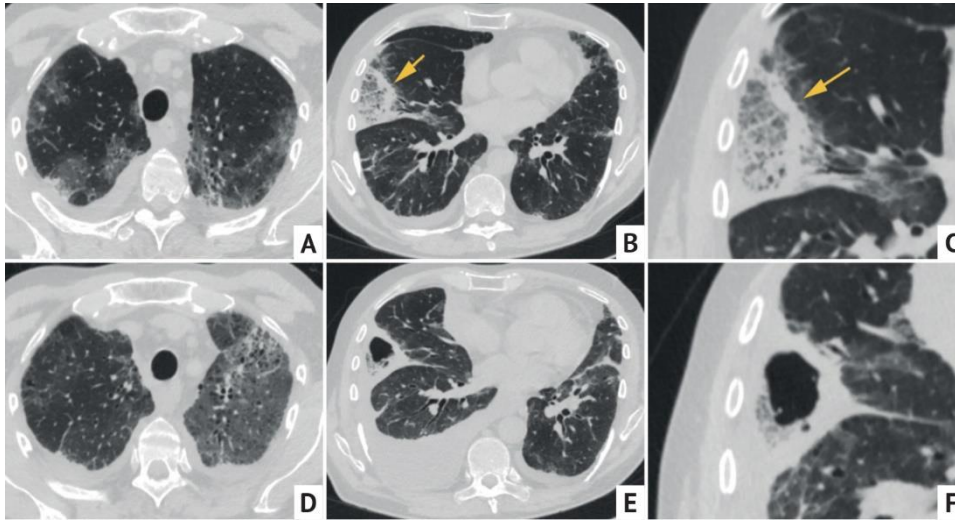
Axial chest CT images of a 65 y.o patient with COVID-19 and pulmonary embolism (with infarction in the right middle lobe) from 15.10.2020 (A–C) and from 22.10.2020 (D–F) at the corresponding levels. In the middle right lobe, a reversed halo sign type opacity (arrows) is clearly visible. A week after the initial study, lung cavitation appeared in the infarction site, and pleural effusion increased. Nodules and other cavities are not detected
